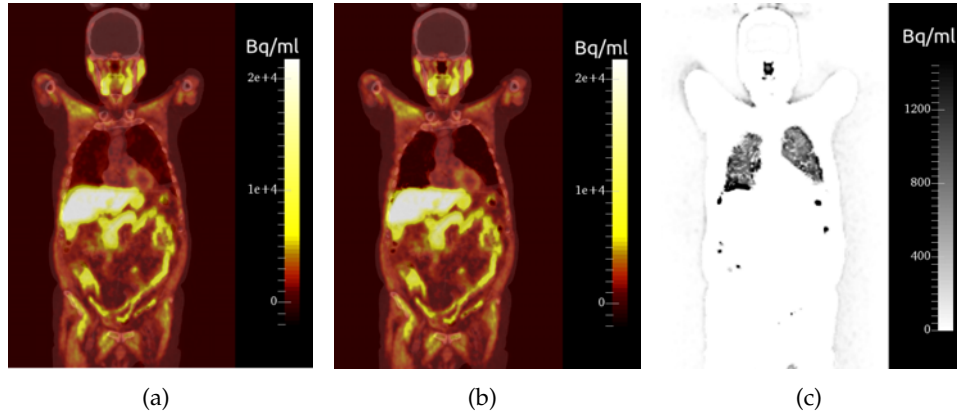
Coronal slices of the native PET (a) and filtered PET (b) fused with CT (for visual morphological reference), and the logical difference between the two (c).
